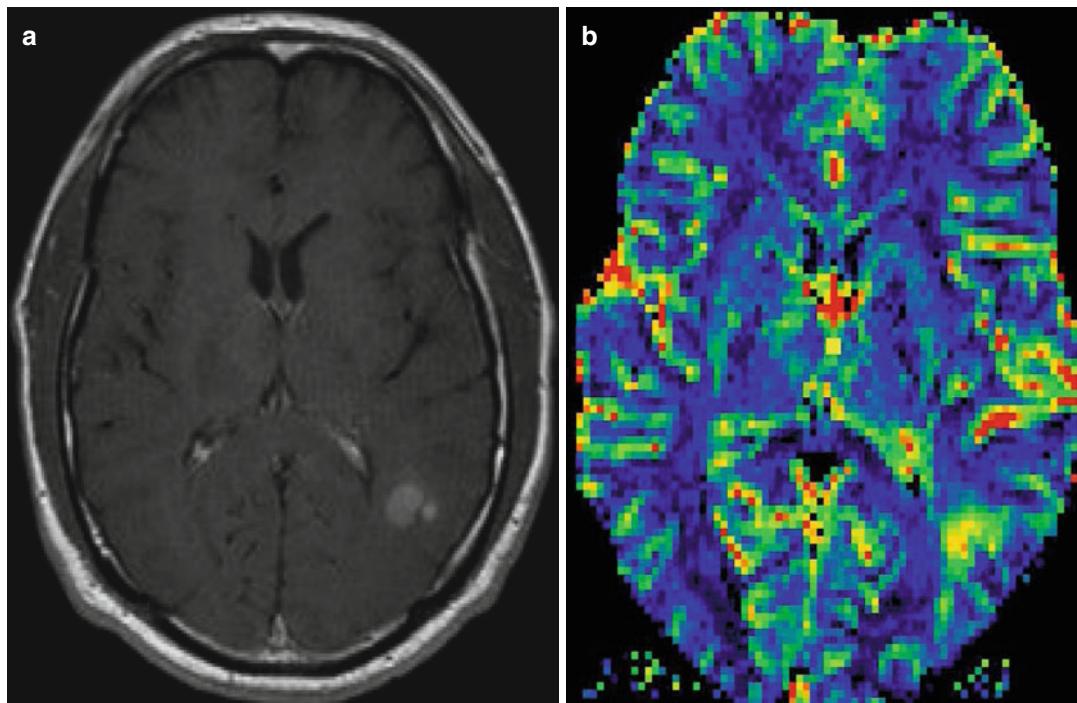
DSC perfusion MRI in a patient with recurrent high-grade glioma. The new contrast-enhanced nodule appeared at the superior border of the resection cavity.
